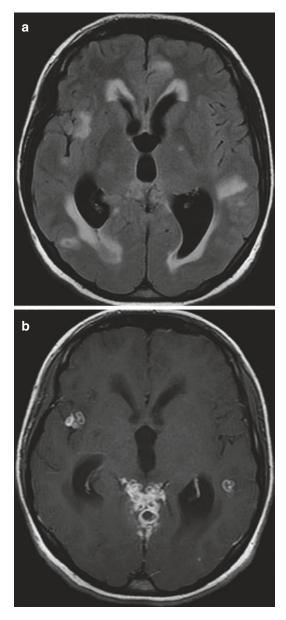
Axial FLAIR (a) and contrast-enhanced T1-weighted images (b) show hydrocephalus and tuber-culomas (Courtesy of I. Sebnem Orguc)
